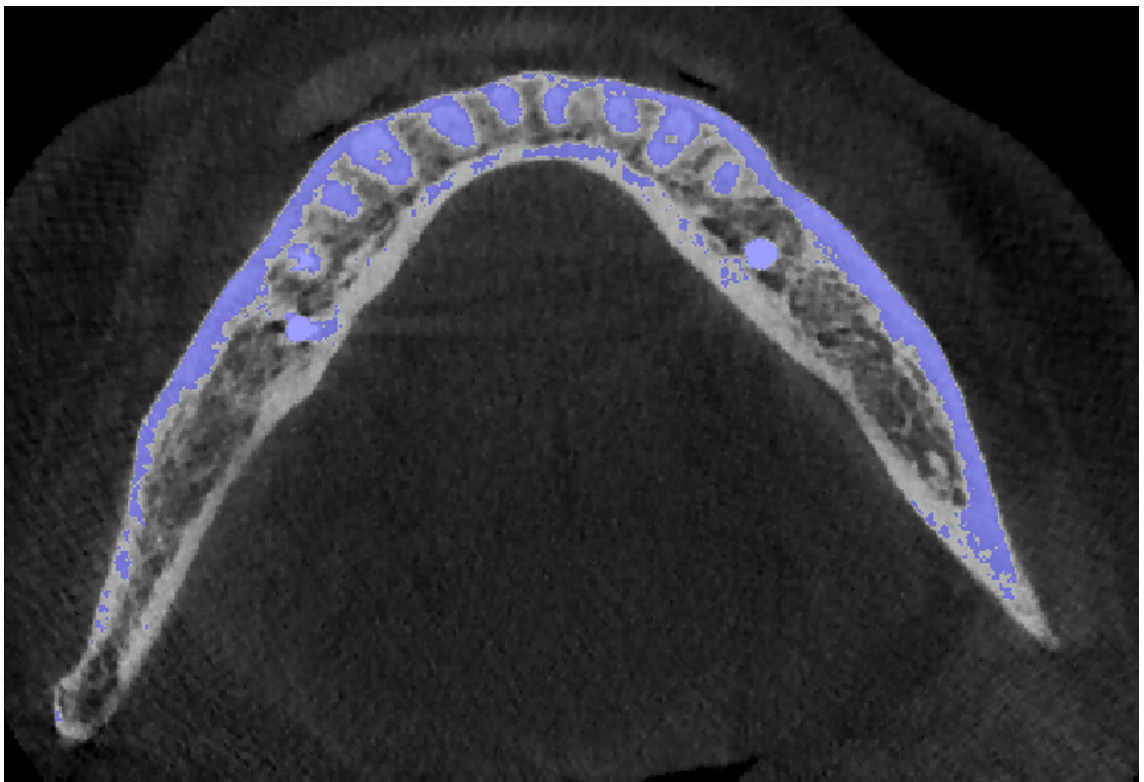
Example of segmentation using a “threshold” function. This picture shows how the separation between cortical and cancellous bone is not easily detectable, neither via morphology nor via density (in this case CT numbers above a certain threshold value are coloured in violet).
